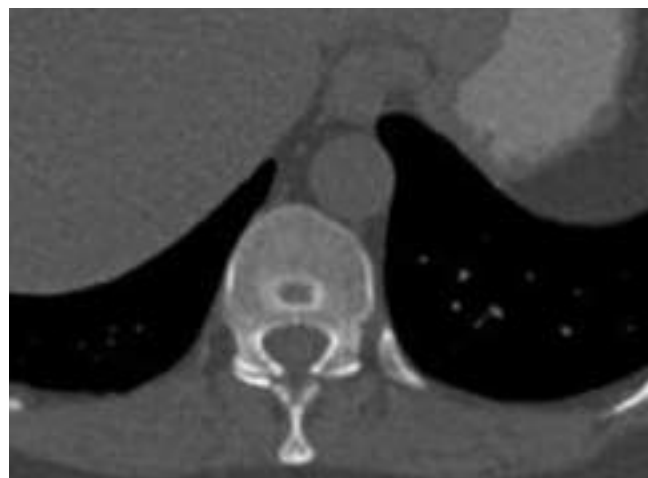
Axial CT images in bone window showing Schmorl's node
